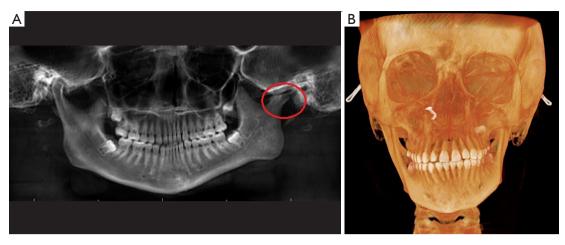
Dento-facial deformity secondary to unilateral TMJ DJD. (A) Panoramic radiograph of a 16-year-old female with unilateral, leftsided TMJ arthritis (red oval outline). Note steeper antegonial notching on the left. This often indicates that resorption occurred during growing years of life before skeletal maturity. (B) 3D reconstruction of the same patient. Note maxillary and mandibular canting, unilateral crossbite malocclusion, and jaw asymmetry secondary to growth disturbance in the maxillofacial skeleton secondary to left condylar DJD. TMJ, temporomandibular joint; DJD, degenerative joint disease.
